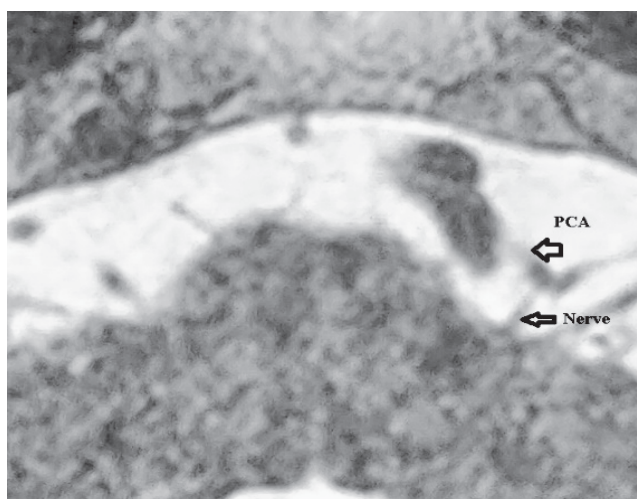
Axial 3D T2 Drive MR image.
